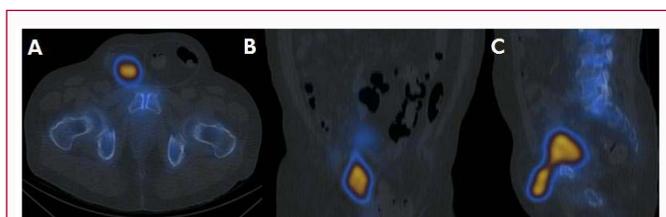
Trans axial (A), coronal (B), sagittal (C) Fused SPECT-CT images revealed increased ^{99m}Tc -MDP uptake in the right inguinal region, which appears separate from the main bladder activity.
